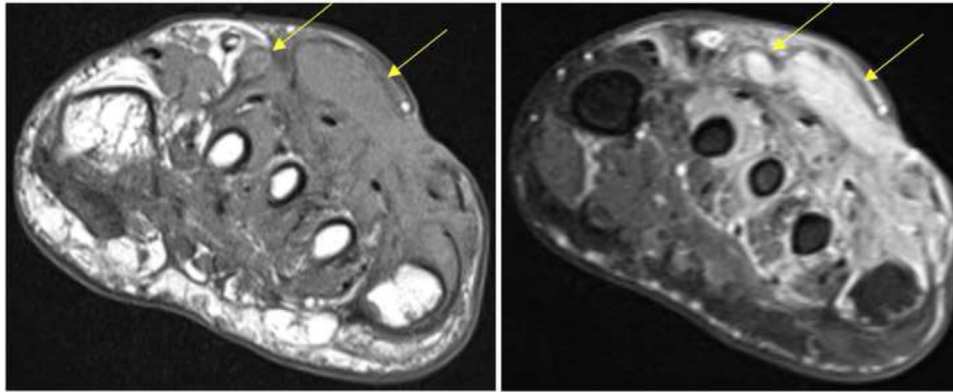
Case 1. Axial MRI sections in regular T1 (A) and fat-suppressed T1 weighting after intravenous injection of gadolinium (B), showing several round-to oval-shaped isointense lesions involving the subcutaneous tissue of the dorsum of the foot, enhanced after gadolinium injection, with peripheral low-signal-intensity fibrosis in between, corresponding to mycetoma grains.
